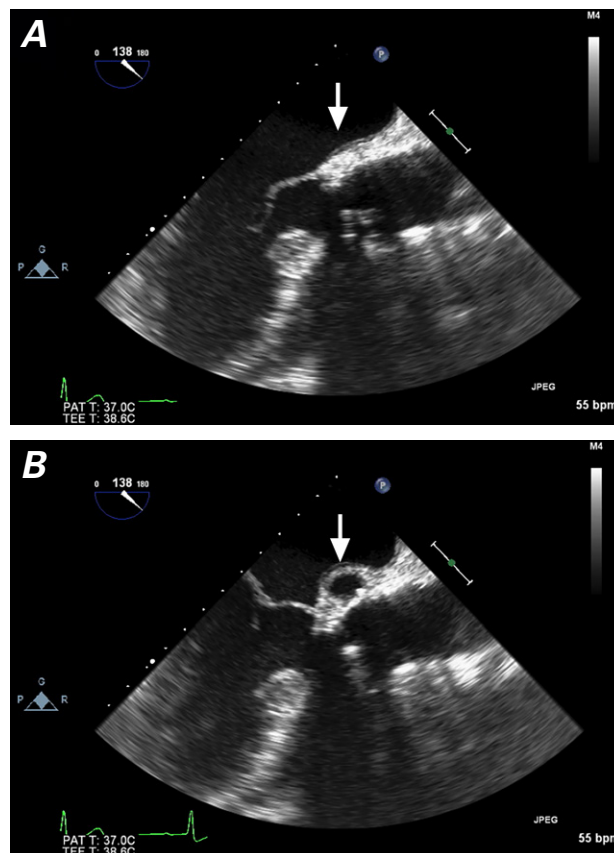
Preprocedural transesophageal echocardiograms obtained during A) diastole and B) systole show the bioprosthetic aortic valve homograft and a pseudoaneurysm (diameter, 1.5×1.7 cm) at the base of the aortic root, adjacent to the fibrous trigone. Pulsatile expansion of the pseudoaneurysm (arrow) occurred during systole.
